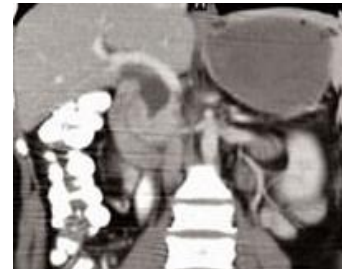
Helical CT - Reconstructed image showing fusiform dilatation of CBD in Type 1 Choledochal cyst.
